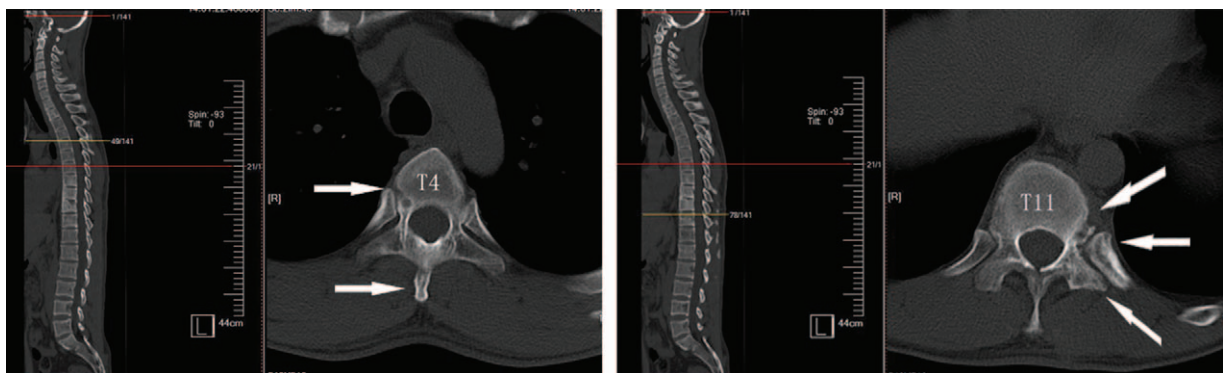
Computed tomographic images of T4 and T11 segments at 18-month follow-up. Compared to Fig. 2, the imaging revealed that osteolytic lesions are healed apparently at the joints of the vertebrae, adjacent ribs, and the posterior elements (neural arch and spinous processes) without the paraspinous soft tissue edema.
